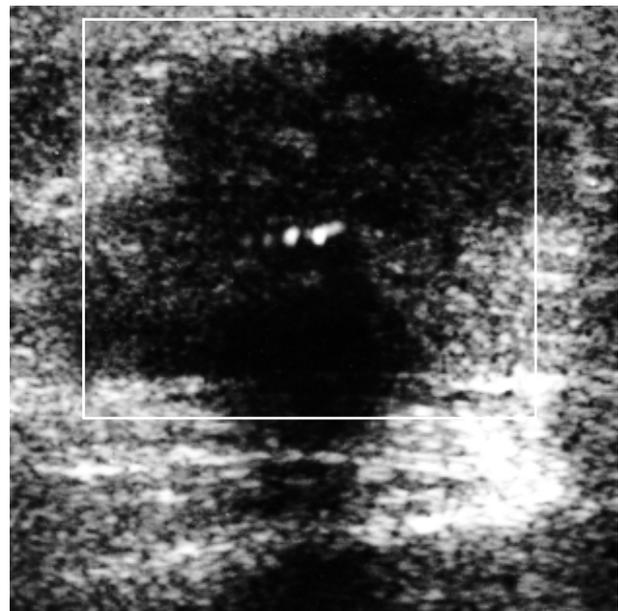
Ultrasonogram of the right upper anterior chest wall shows an irregular, poorly defined hypoechoic mass measuring 1.8 × 2.8 cm without significant color Doppler signals.
